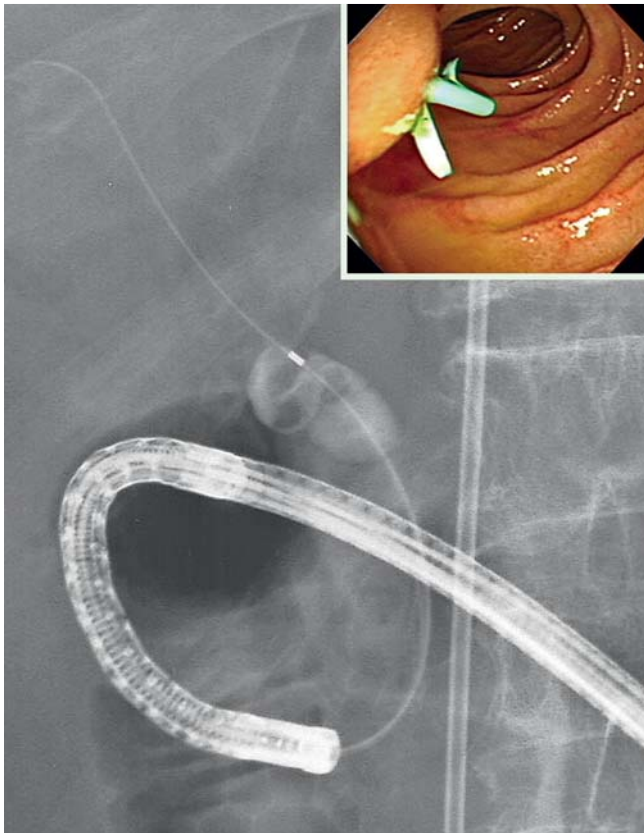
Ultraslim endoscopic biliary stenting via a gastrostomy: radiograph showing the ultraslim endoscope in the papilla. Note the scope entering the stomach via the abdominal wall and not via the esophagus. A catheter was advanced into the bile duct, and a cholangiogram showed filling defects because of stones in the bile duct. Finally, a 5-Fr biliary stent was placed (inset).
